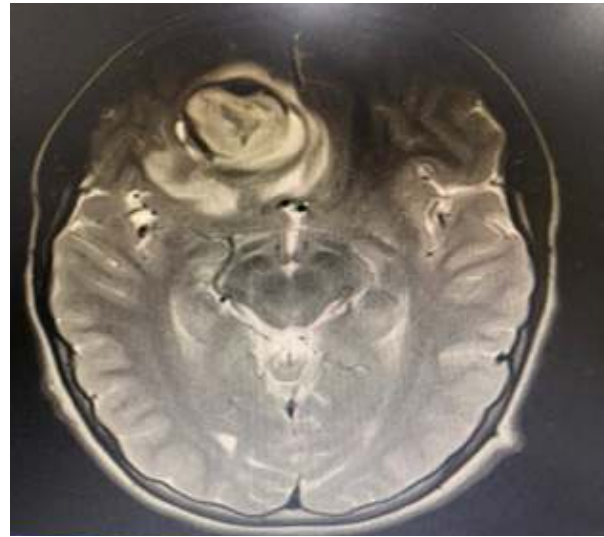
Coronal MRI section of the brain Cavernoma Zabramski 1
